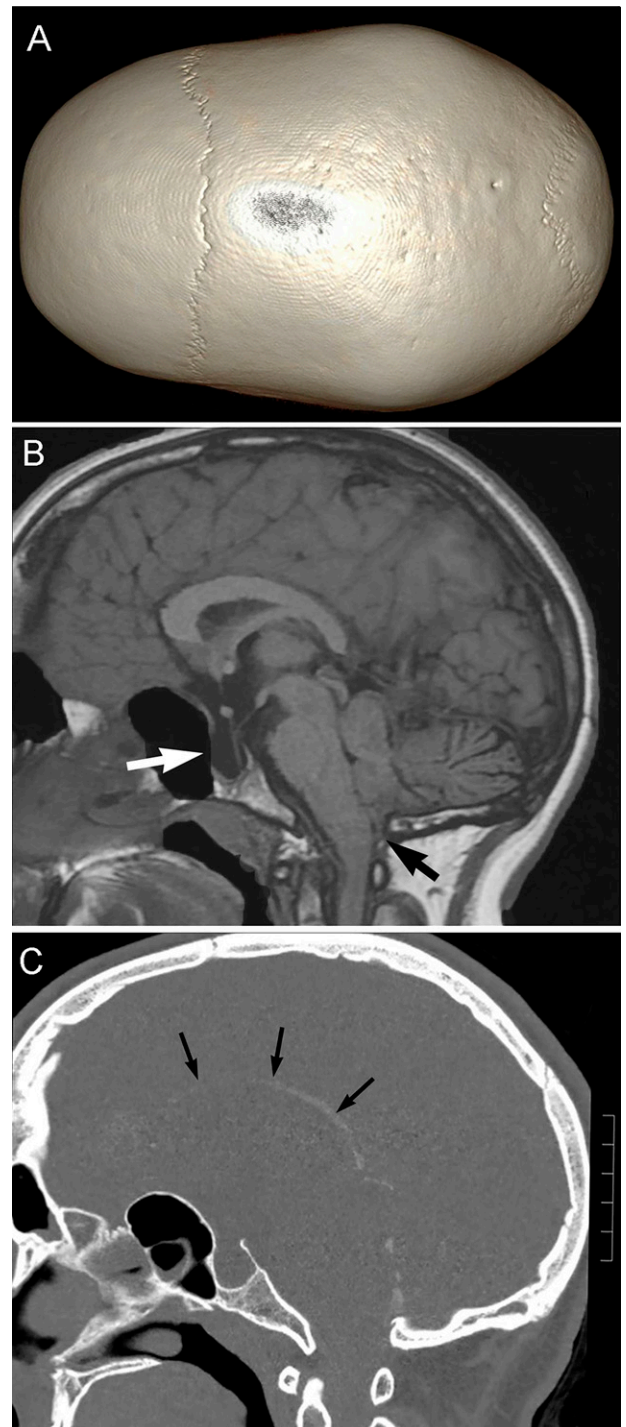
Head and brain anomalies. A: Three-dimensional reconstruction computed tomography (CT) demonstrating absence of the sagittal suture with scaphocephaly. B: Noncontrast sagittal MRI showing small posterior fossa, platybasia, cerebellar tonsillar herniation (*black arrow*), narrow foramen magnum, hypoplasia of the posterior corpus callosum, and pronounced enlargement of the sella turcica (*white arrow*) with an elongated pituitary stalk and partially empty appearance. C: Noncontrast sagittal CT showing calcification along the inferior border of the falx cerebri (*arrows*) and at its junction with the tentorium.
